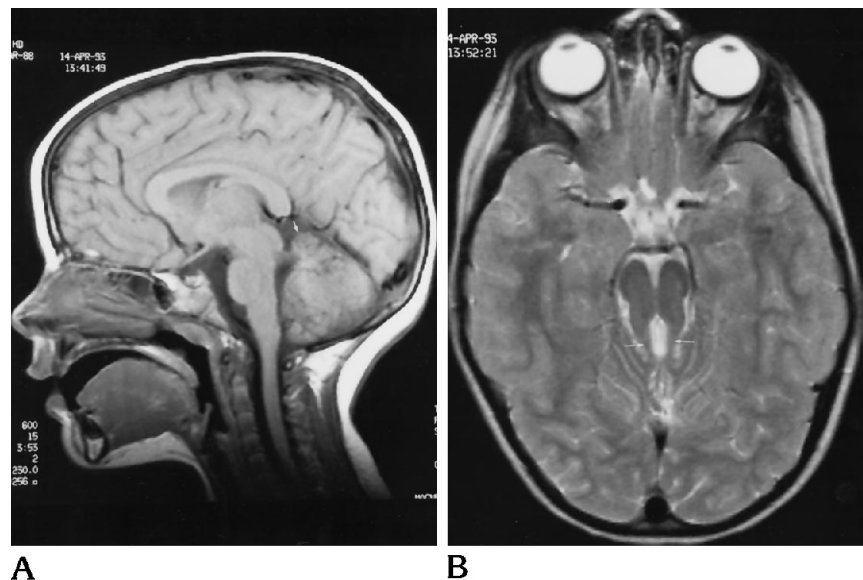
A, Midline sagittal T1-weighted image (600/15/2) shows dysgenetic rostral vermian lobules (*arrow*) and absence of the remaining vermis. The superior cerebellar peduncles are abnormal and produce flattening of the rostral fourth ventricle, which is abnormal in shape; the foramen of Magendie is patent. There is no intercollicular sulcus, and the superior and inferior colliculi appear to be fused. The corpus callosum is normal.
